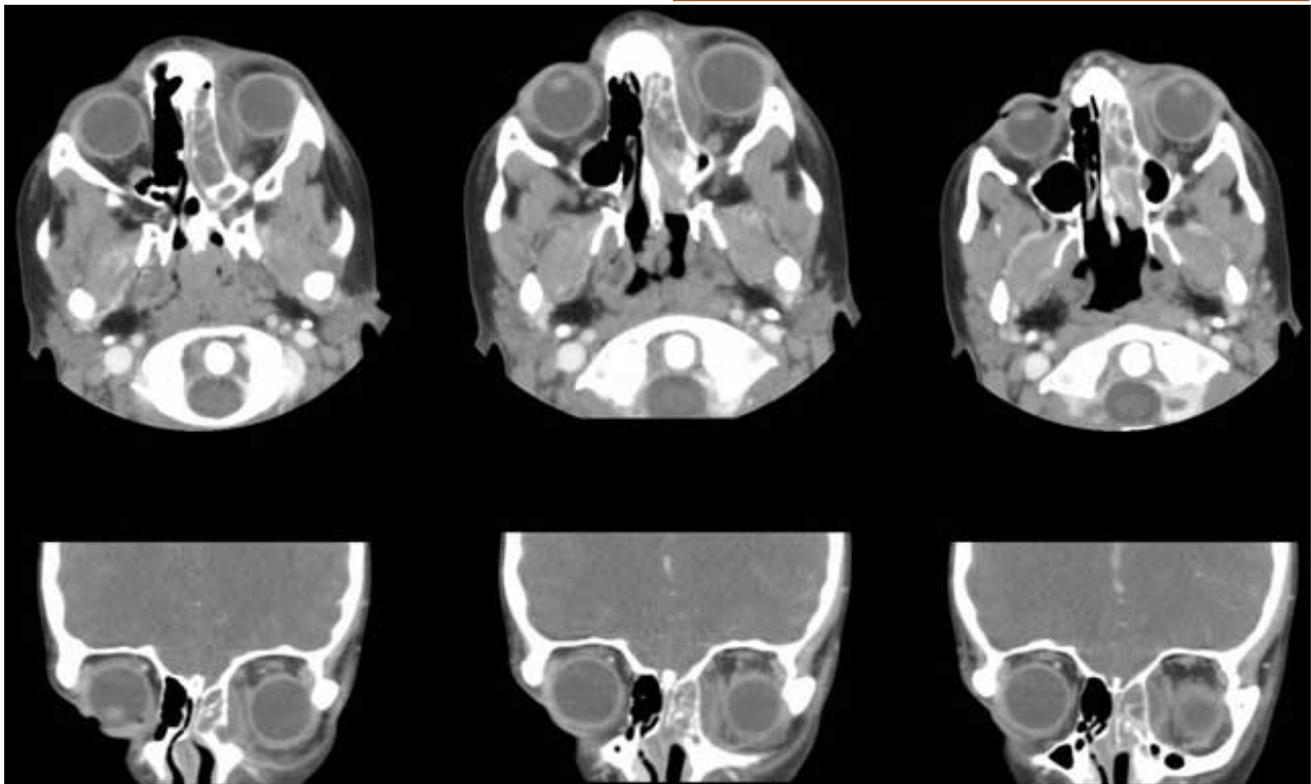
CT max/face: Subperiosteal abscess formation adjacent to the lamina papyracea of the left orbit with extensive sinusitis involving the left ethmoid sinus
